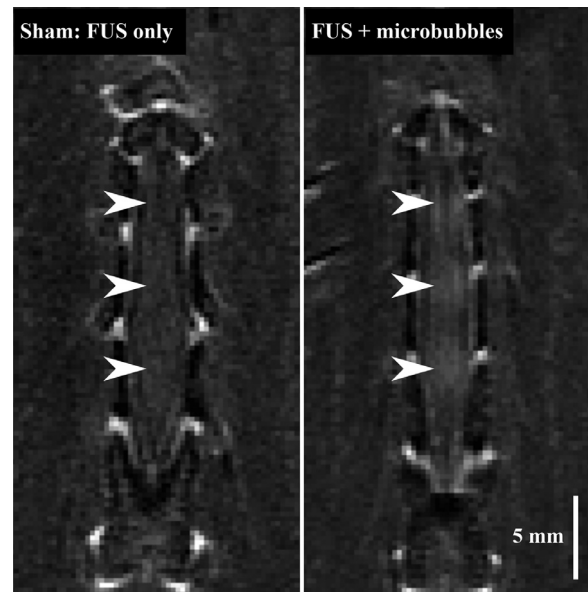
Representative post-treatment T<sub>1</sub>-weighted, contrast-enhanced magnetic resonance images comparing enhancement in (left) the group with focused ultrasound only and (right) other treatment groups using focused ultrasound and microbubbles (taken from the pulse-length group). The white arrows indicate the target treatment locations.
